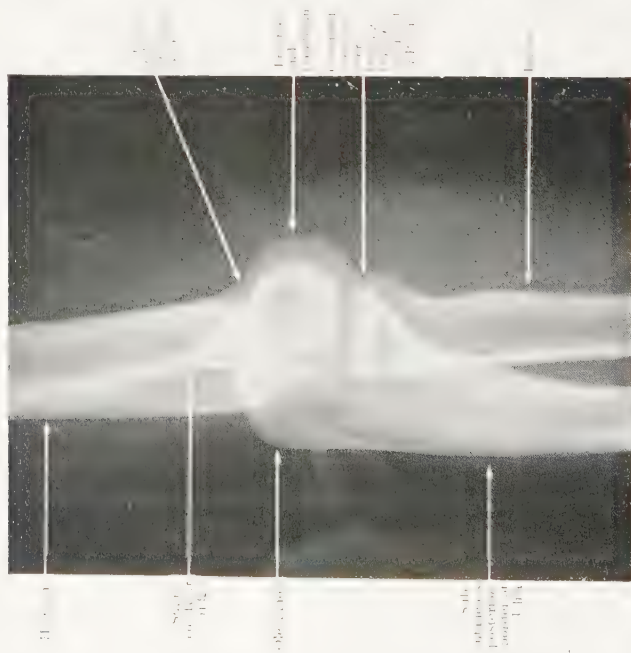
Lateral Radiograph of same Elbow as in Fig. 83 fully extended. Note the tip of the olecranon in the olecranon fossa of the Humerus
